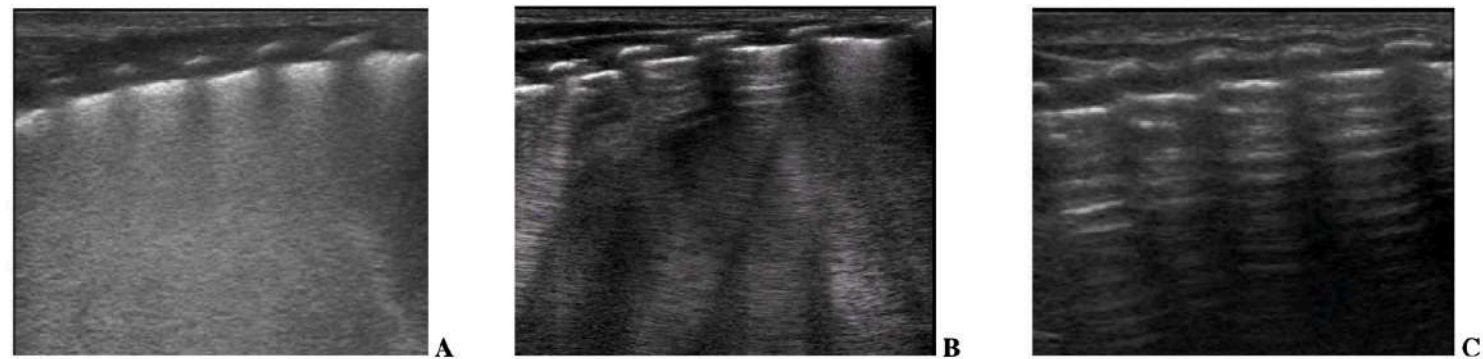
Neonatal lung ultrasound profiles. A) Type 1- full hyperechoic image of the lung fields or 'white lung'; B) Type 2- prevalence of B lines, that is, vertical, comet-tail artifacts; C) Type 3- predominance of A lines, that is, horizontal repetitions of the pleural line.
